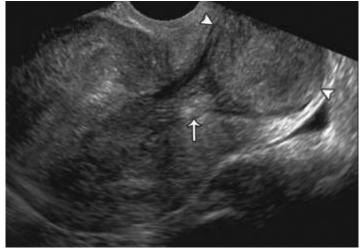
A solid mass with internal echogenicity similar to that of the myometrium is shown in this sonographic image, which is depicted by an arrowhead. The mass has a stalk like attachment extending from the uterus till the cervical canal as shown by the arrow.
